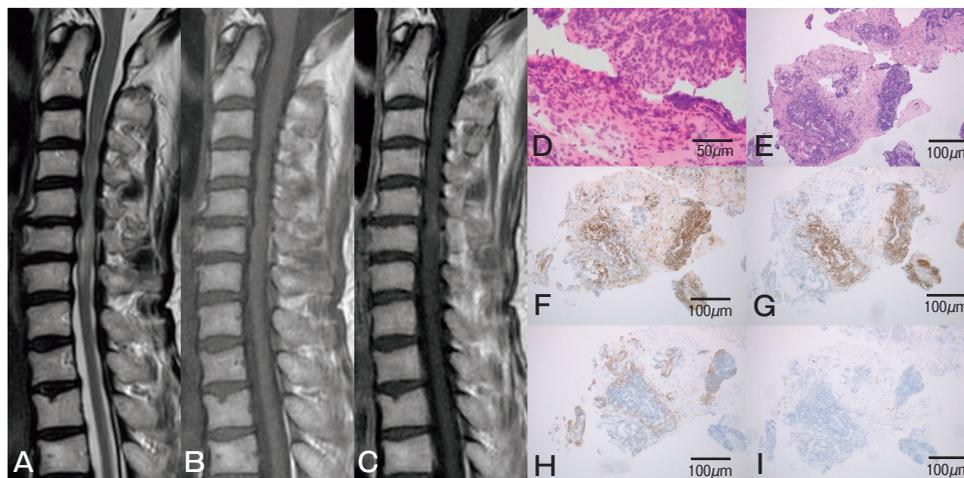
Case 3. High-signal-intensity T2-weighted MRI (A), iso-signal-intensity T1-weighted MRI (B), and Gd-DTPA-enhanced tumor (C). IPD: high nucleus-to-cytoplasmic ratio (malignant lymphoma) (D). FPD: No evidence of malignant lymphoma (E), Cluster of differentiation CD3+ (F), CD20+ (G), CD138+ (H), cyclin D1- (I).
